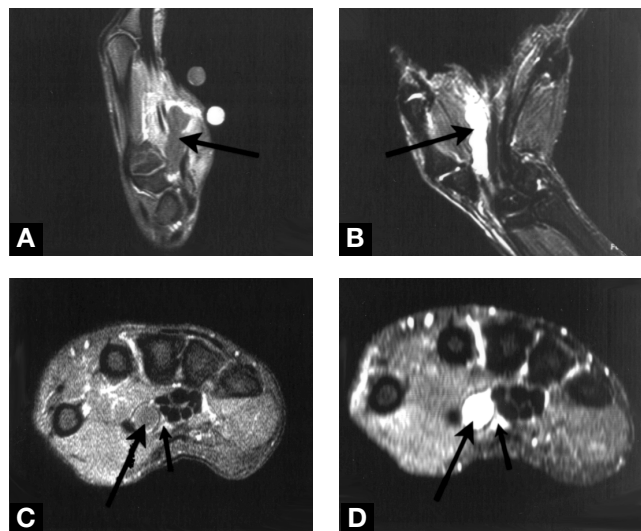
Magnetic resonance images. (A) T₁-Weighted sagittal (postcontrast) and (B) T₂-weighted short tau inversion recovery (STIR) coronal images demonstrating large homogenous carpal mass. (C) T₁-Weighted and (D) T₂-weighted STIR axial images demonstrating carpal mass (large arrows) compressing median nerve (small arrows).
